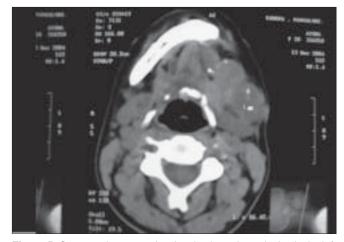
Computed tomography showing hypodense lesion in the left submandibular region with small areas of calcifications
